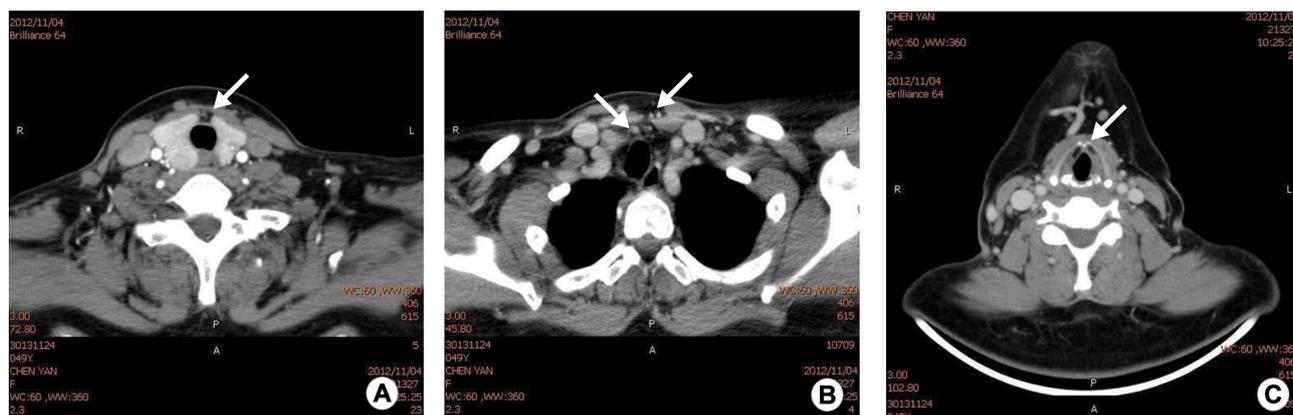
Signs of PTC metastatic LN in CT in a female PTC patient aged 43 years. A: White arrow shows the central area of the upper anterior thyroid with low-density masses with fuzzy boundaries. B: White arrows show lesions that are moderately enhanced, enlarged LN can be seen in the right side of neck, with necrosis in LN. C: White arrow shows the central region of the of the upper thyroid that has also a number of small nodules with punctate calcifications in the lesions. No affected signs are found in the cricoid cartilage, carotid sheath and sternocleidomastoid.
